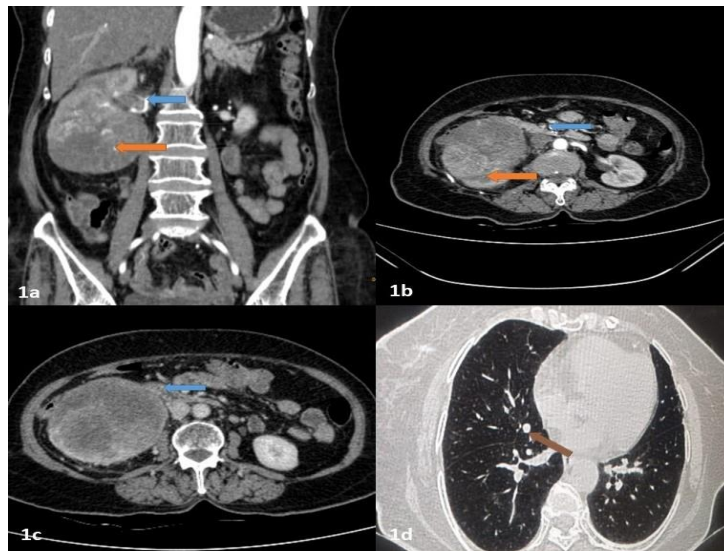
Coronal section arterial phase showing tumour in lower polar and interpolar region (orange arrow) and thrombus enhancement (blue arrow). Fig. 1b. Transverse section arterial phase with heterogeneous tumour (orange arrow) showing enhancement as well as thrombus (blue arrow). Fig. 1c. Thrombus showing enhancement involving the right renal vein up to its drainage into the infrarenal IVC. Fig. 1d. High-resolution CT Thorax suggested well-healed COVID-19-related pneumonia with a perifissural nodule in the medial segment of the right middle lobe (brown arrow).
